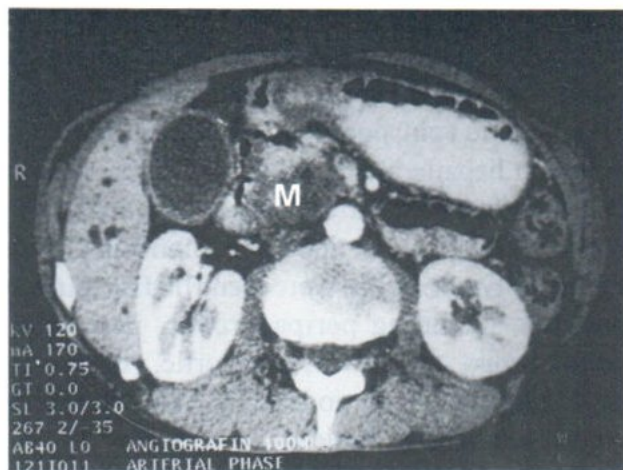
The arterial phase dynamic CT scan showed a 4 cm. low density lesion at pancreatic head. (M)
